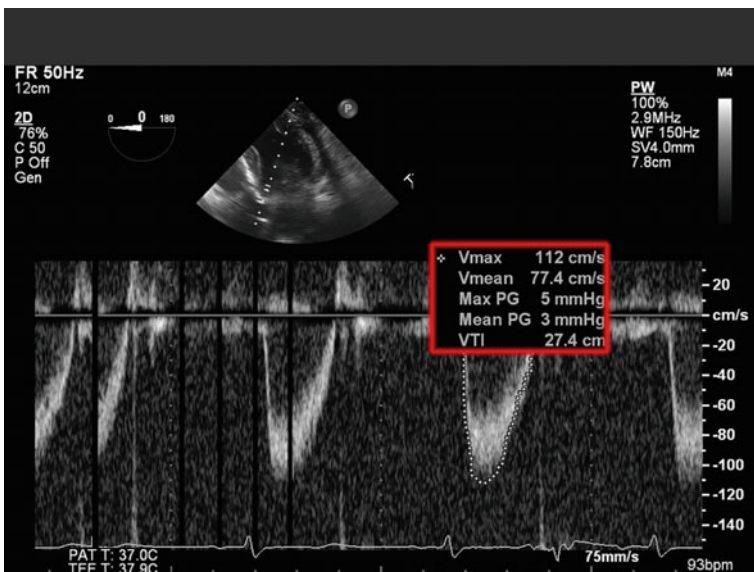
Spectral profile from pulse wave Doppler placed in the left ventricular outflow tract in a Deep transgastric long axis view. Tracing the profile provides the velocity time integral (stroke distance)
